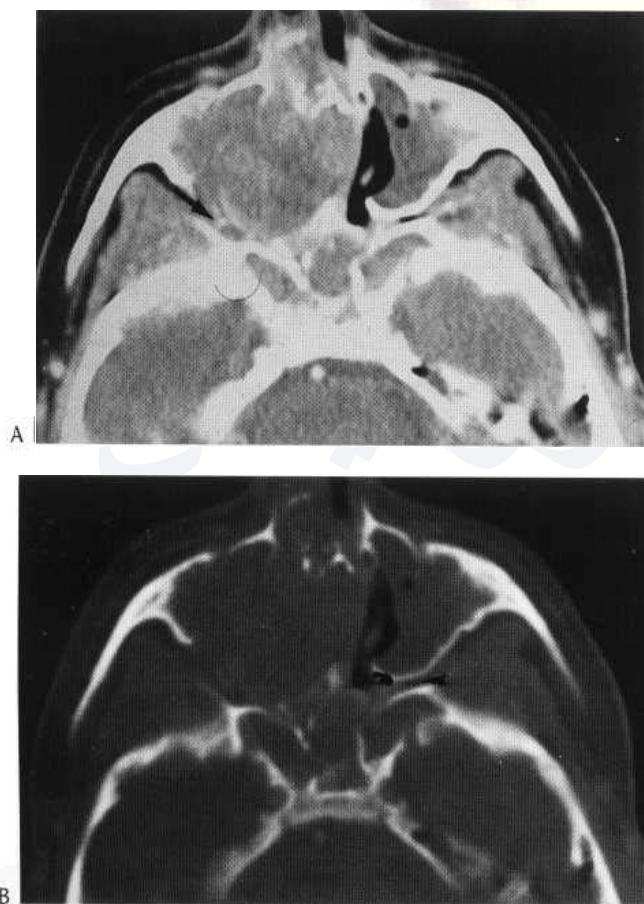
Axial CT scans displayed on soft tissue (A) and bone (B) window settings show a large soft-tissue mass involving the right maxillary antrum. There is destruction of the posterolateral wall of the right maxillary antrum and abnormal soft tissue is seen extending into the infratemporal fossa and right pterygopalatine fossa (arrow). Note the normal-appearing left pterygopalatine fossa (arrowhead).
